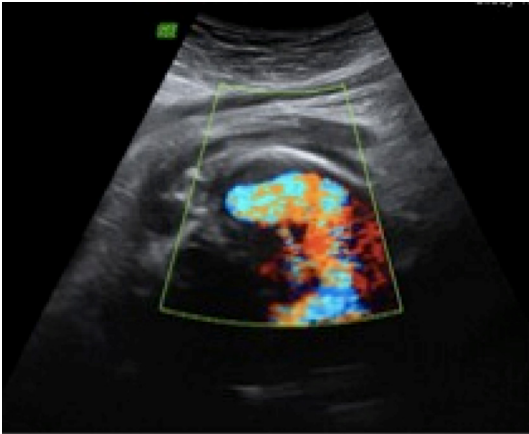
Vascular structure with a turbulent flow under color Doppler ultrasound.
